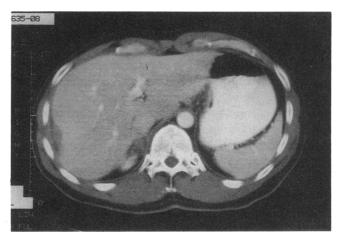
Repeat CT scan 3.5 mo after injury shows complete resolution of the laceration and minimal residua of the hepatic hematoma.
